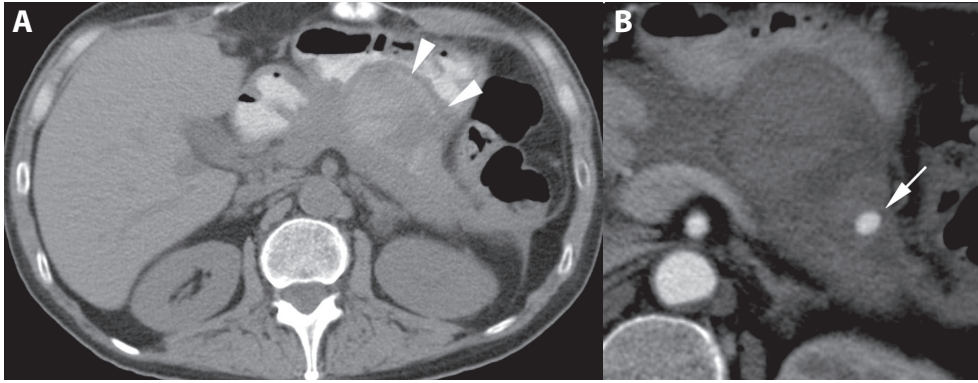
A 40-year-old man with an arterial pseudoaneurysm after an episode of necrotizing pancreatitis. (A) Unenhanced CT shows a collection (arrowheads) with high density, suggestive of hemorrhage. (B) Contrast-enhanced CT in the arterial phase depicts a small arterial pseudoaneurysm (arrow) originating from the prepancreatic arcade. Pseudoaneurysm was successfully treated by embolization with platinum coils (not shown).
